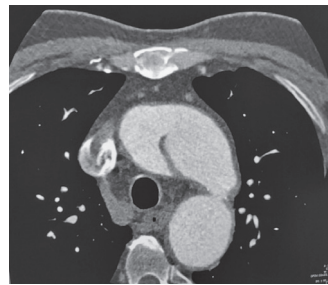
Thorax CT scan showing dissection of arcus aorta at six month follow up period.
